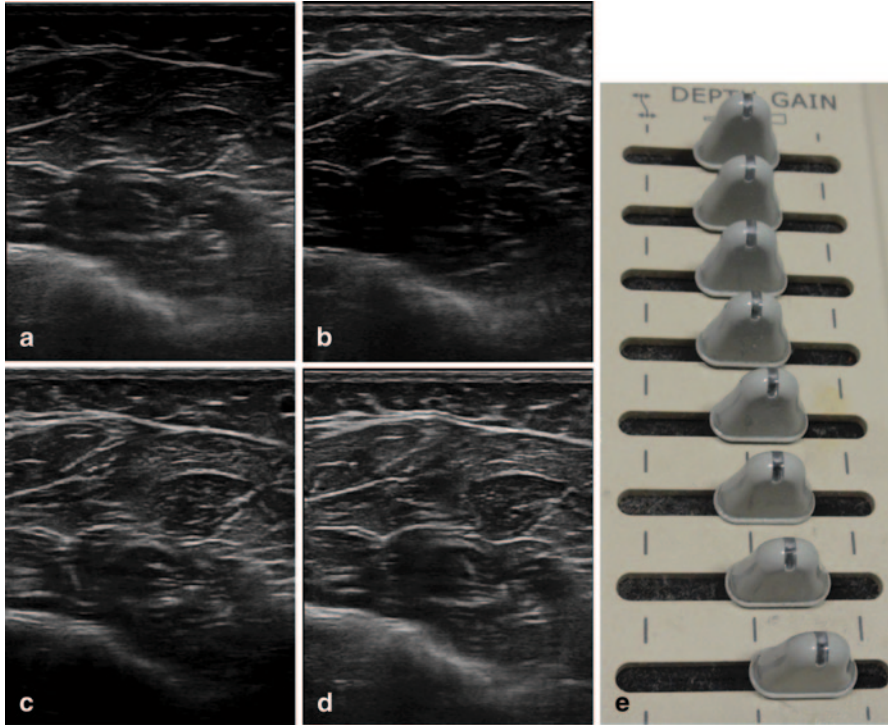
TGC adjustment. a Too low gain in superficial part of the image. b Too low gain in the middle of the ultrasound image. c Too low gain in the deeper part of the image. d Proper gain in the entire image. e The TGC buttons. TGC time gain compensation
